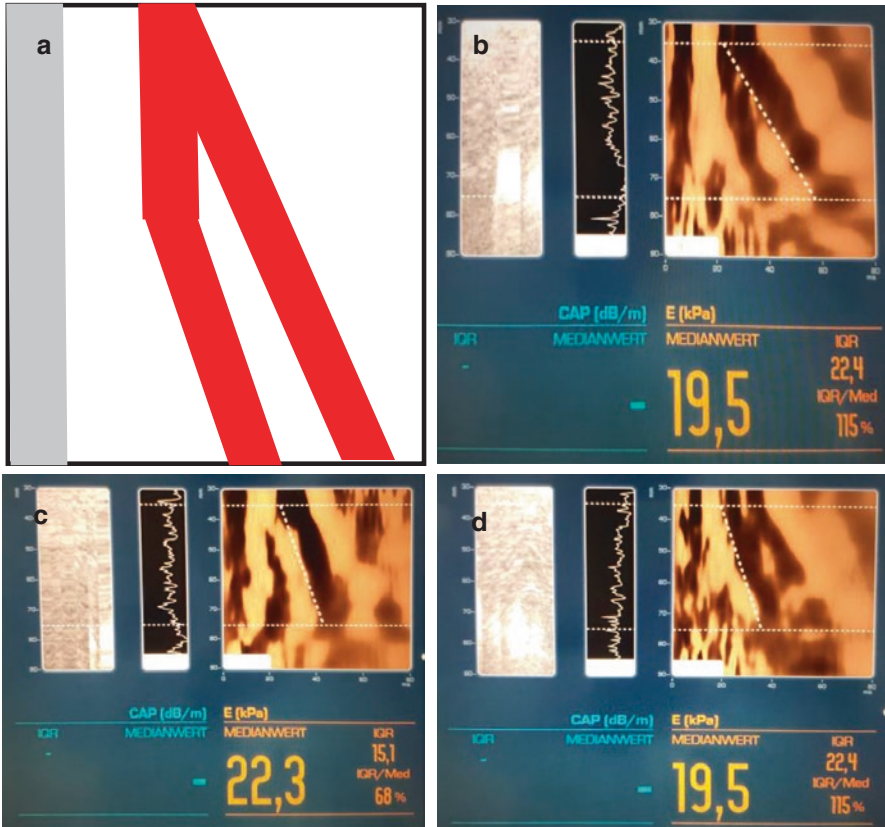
Various examples (a–c) of shear wave interruptions both of compression and *shear* waves. Note that the term compression wave may not be completely correct since only an image artifact of the compression wave is recorded. Imaging of compression waves may be impossible by ultrasound since they travel at the same speed as the ultrasound RF signal used for imaging
